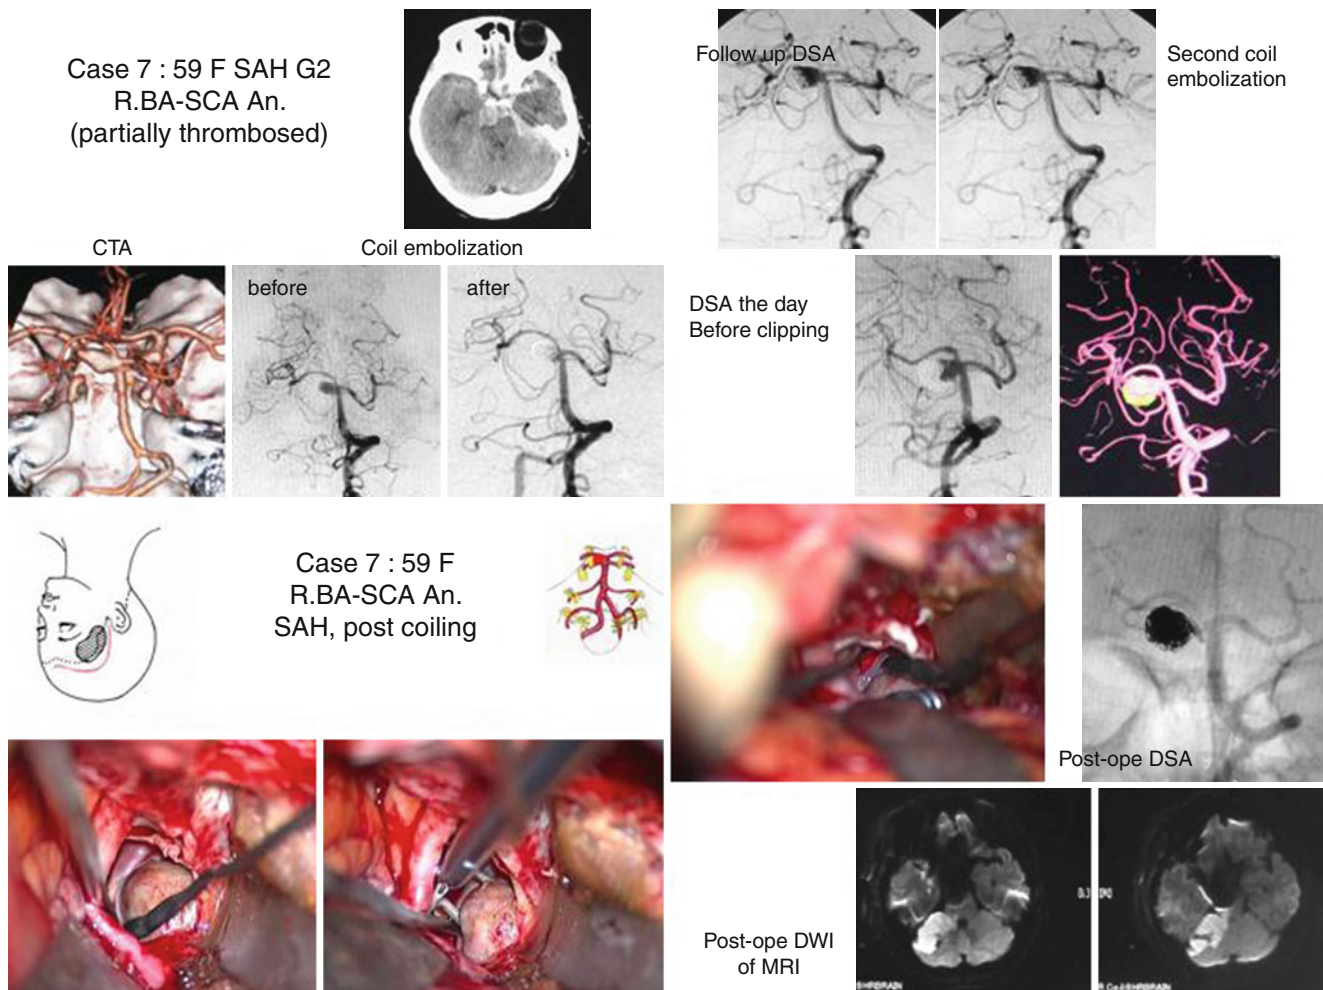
Upper left: CT and DSA of Case 7. Upper right: Follow up DSA of Case 7. Lower left: Intra-operative photographs of Case 7. Lower right: Intra-operative photograph and Postoperative MRI and DSA of Case 7
